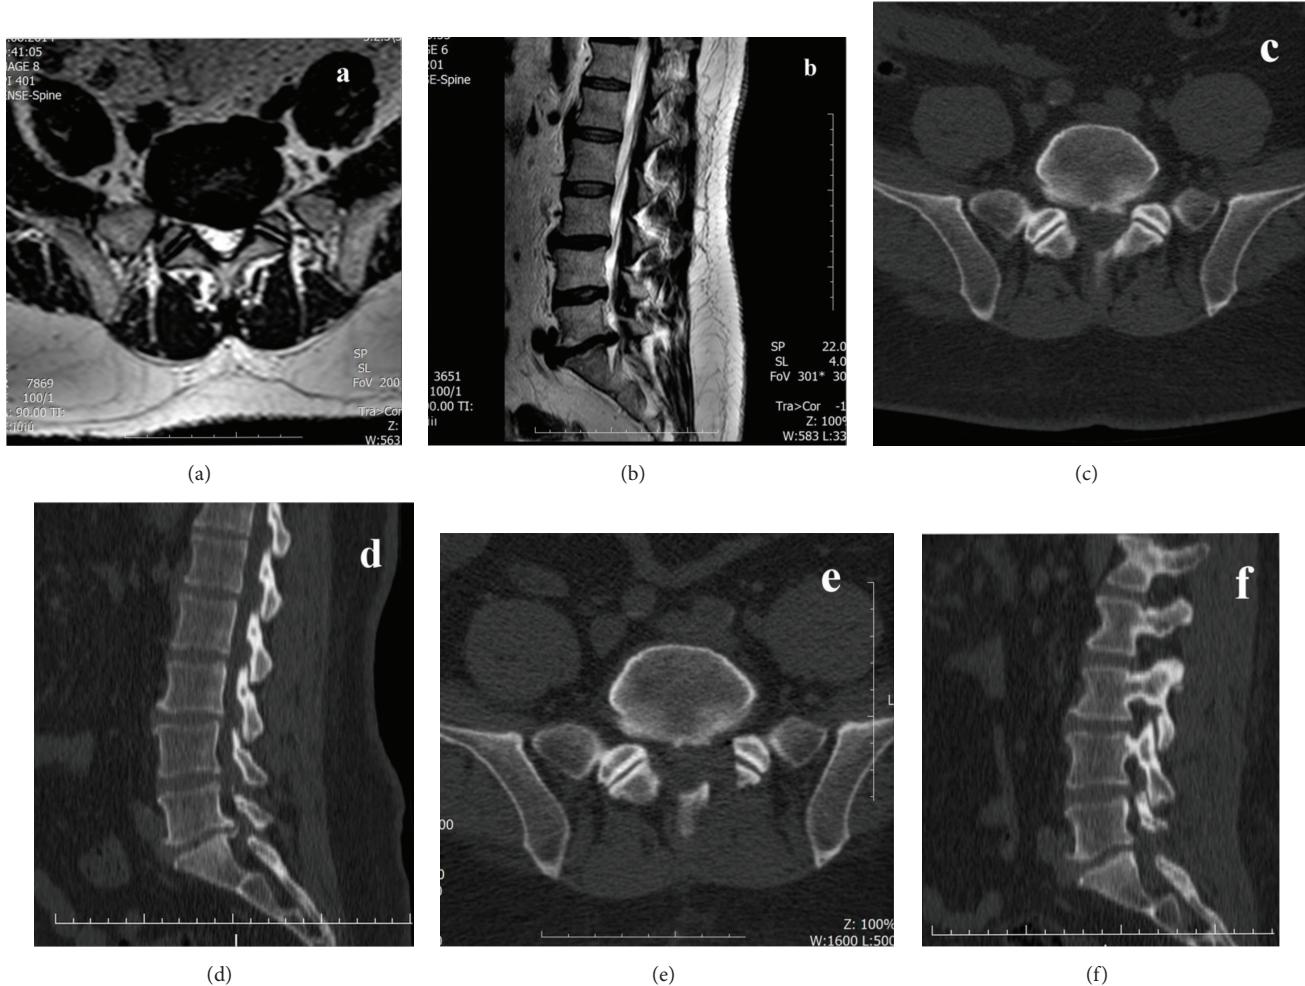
Preoperative (a) axial and (b) sagittal MRI with T2 weighted image and (c) axial and (d) sagittal CT images of a calcified left L5-S1 level disc herniation causing lateral recess syndrome and postoperative (e) axial and (f) sagittal CT images demonstrating decompressed foramen with limited foraminotomy.
